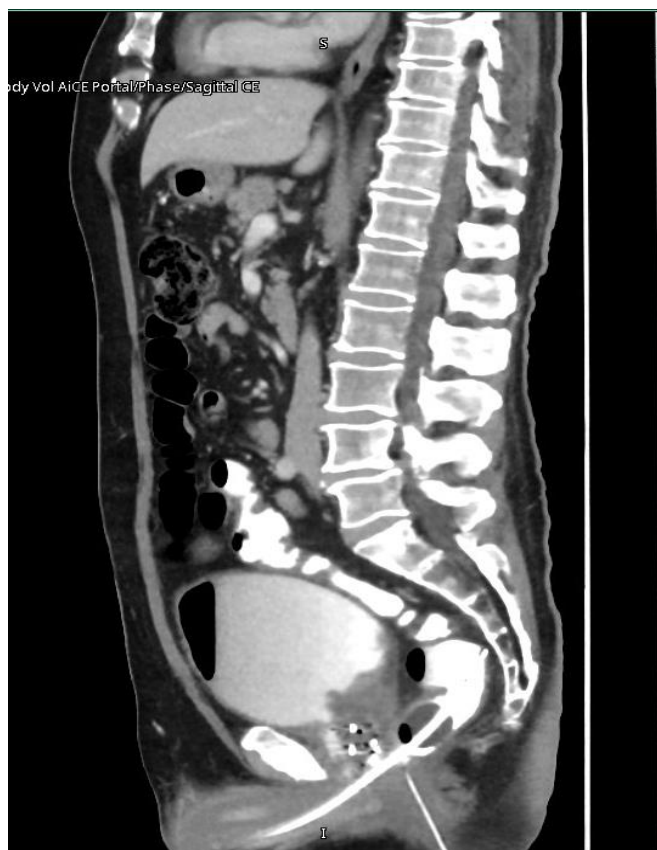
Sagittal view Image from Patient's CT.
